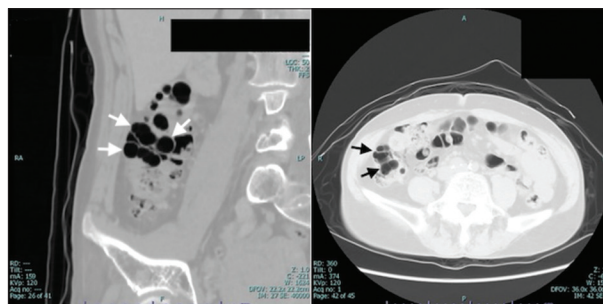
Computed tomography images showing air-filled cysts within the bowel wall of the ascending colon
